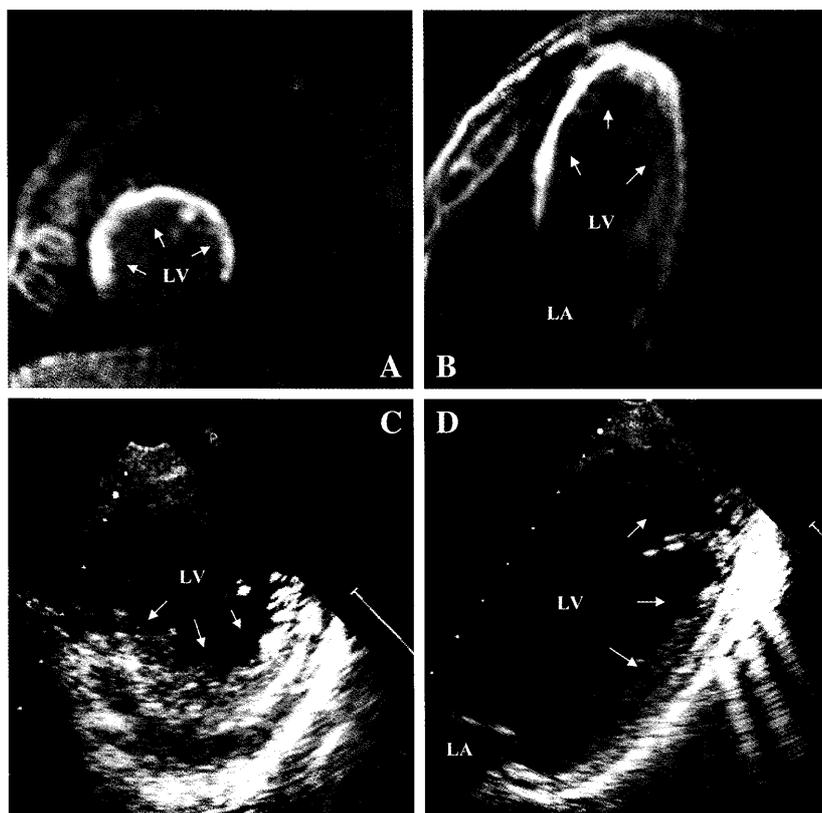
(A,B) Delayed-enhancement magnetic resonance imaging (MRI) 2-chamber view in end-diastole demonstrates hyperenhancement of the trabeculations from the anterolateral to the apex region of the left ventricle (LV) (white arrow). (C,D) Echocardiography in the short-axis view and 2-chamber view demonstrates the trabecular meshwork region from the anterolateral to the apex region of the LV (white arrow) when delayed-enhancement MRI was performed. LA, left atrium.
